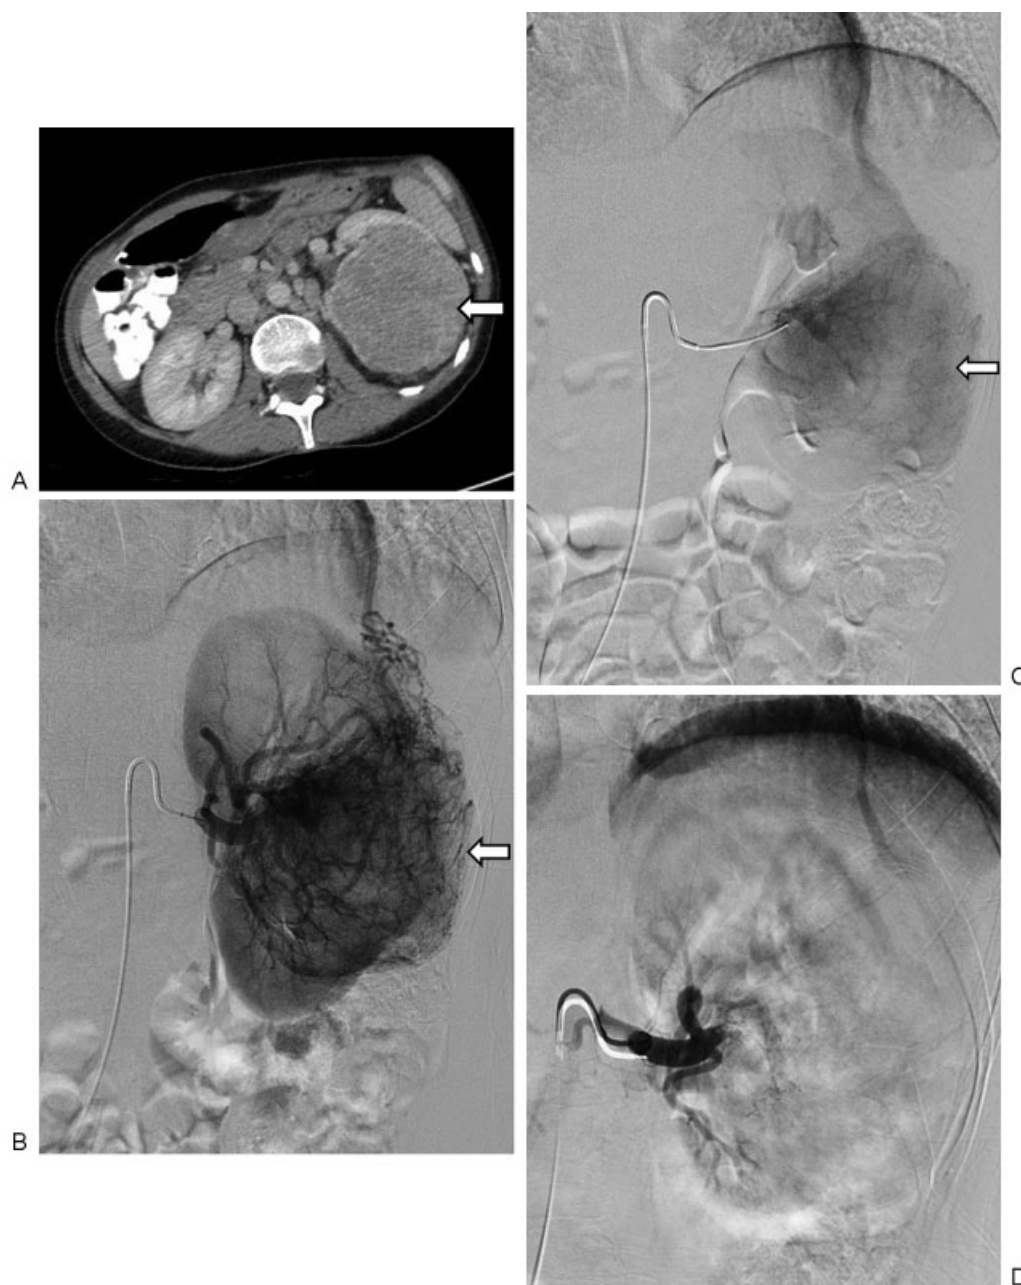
A 53-year-old woman with 11.7 cm left renal cell carcinoma that underwent preoperative left renal arterial embolization followed by uneventful left nephrectomy with a reported total estimated blood loss of 300 mL. (A) Axial contrast-enhanced computed tomography image of the enhancing left renal mass (arrow). (B) Selective left renal arteriogram demonstrating a large hypervascular renal cell carcinoma (arrow) before embolization. (C) Microcatheter-mediated embolization of the hypervascular mass using tris-acryl gelatin microspheres to stasis. Note the decreased regions of tumor vascularity (arrow). (D) Postembolization selective left renal arteriogram demonstrating near-complete embolization of the left renal artery to stasis.
